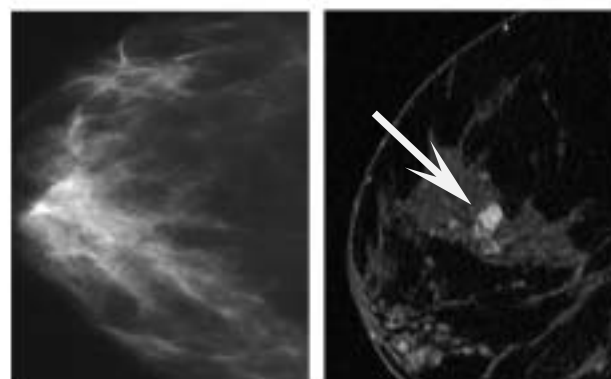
Breast MRI (shown on right) demonstrates a 7mm enhancing lesion that corresponds to a 5cm high-grade DCIS with comedo-necrosis in patient with BRCA1 mutation; lesion was missed on mammogram (shown on left).
